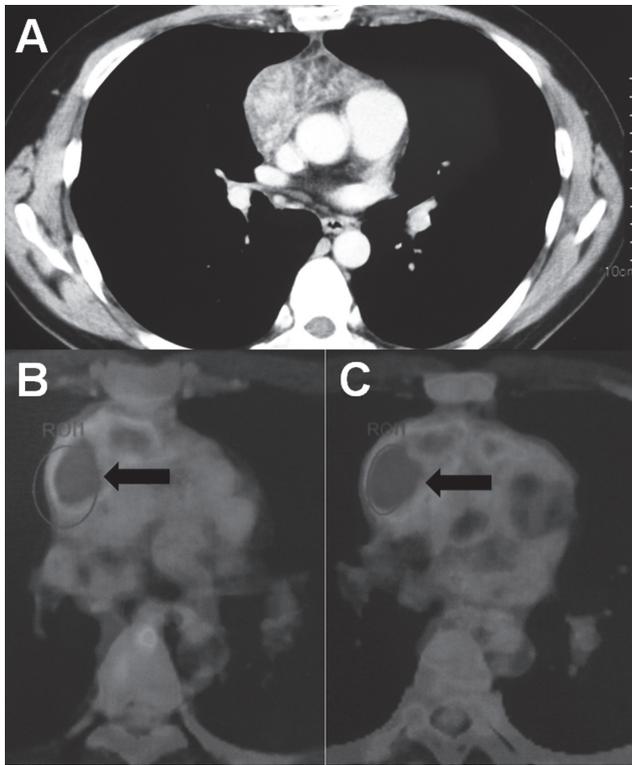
(A) Chest computed tomographic (CT) scan showing anterior mediastinal swelling. (B, C) Dual phase ^{18}F -FDG-PET CT images. (B) Image of the early phase (60 min) shows the positive up-take (arrow). SUVmax is 5.93. (C) Image of the late phase (120 min) SUVmax is 8.92.
